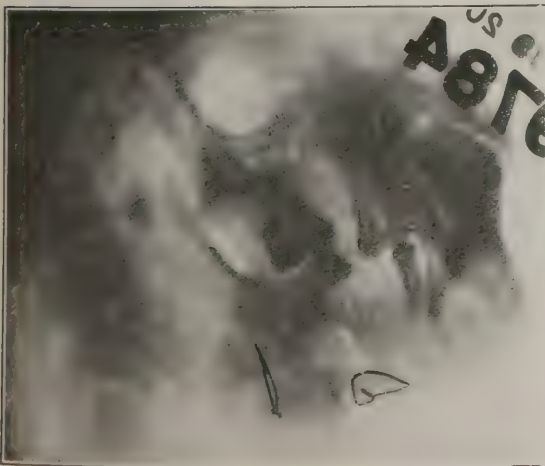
Case 10: Radiograph five months
